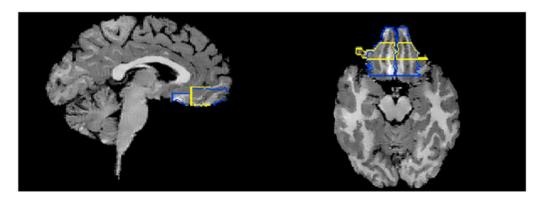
MRI sagittal and transverse view showing Abi-Dargham criteria (Abi-Dargham 2002) and Lacerda criteria (Lacerda 2003) for delineating OFC. Note: the Lacerda criteria (outlined in blue) includes the sub genual OFC, whereas the Abi-Dargham criteria (outlined in yellow) does not sample this part of the OFC.
